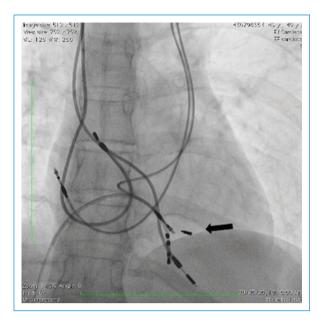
Chest x-ray following extraction of the VDD lead and implantation of a permanent dual chamber pacemaker. Anterior-posterior projection showing the final outcome. The arrow indicates the residual fragment of the extracted lead. The two previously abandoned leads are seen along with the two newly implanted leads.
